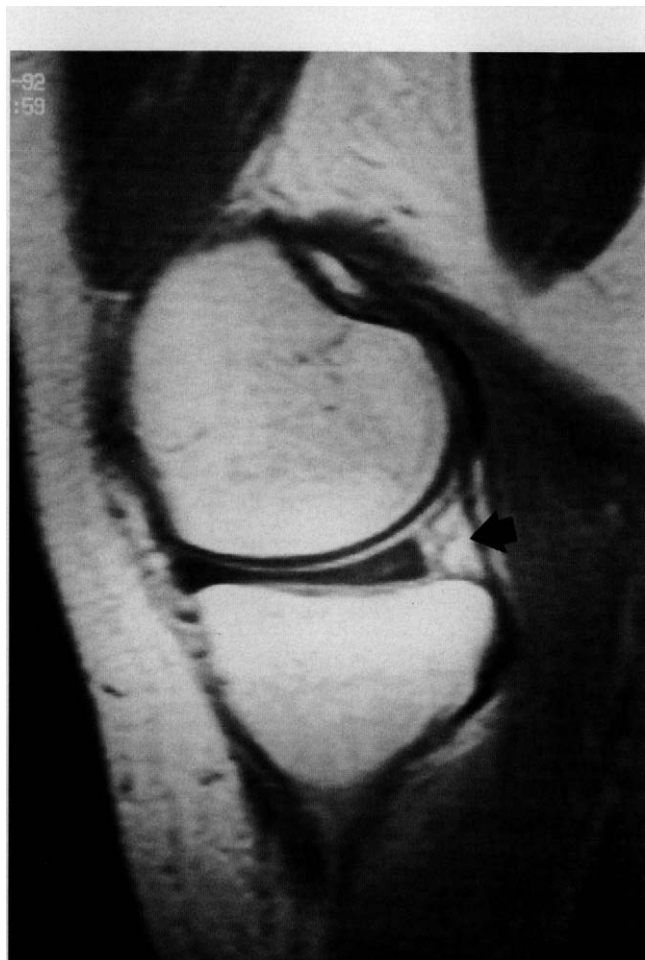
Sagittal section MRI scan demonstrating Grade II signal change of the posterior horn of the medial meniscus (arrow) in an asymptomatic 29-year-old woman.
